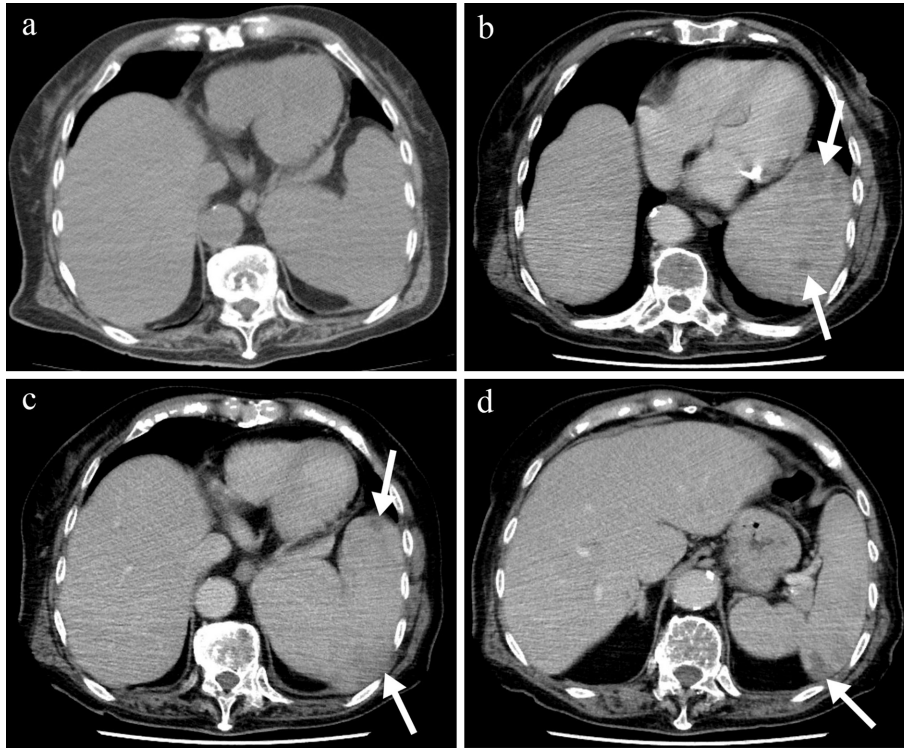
a. Abdominal precontrast computed tomography showing splenomegaly. b-d. Abdominal contrast-enhanced computed tomography showing multiple splenic hypodense lesions and no enlarged lymph nodes.
